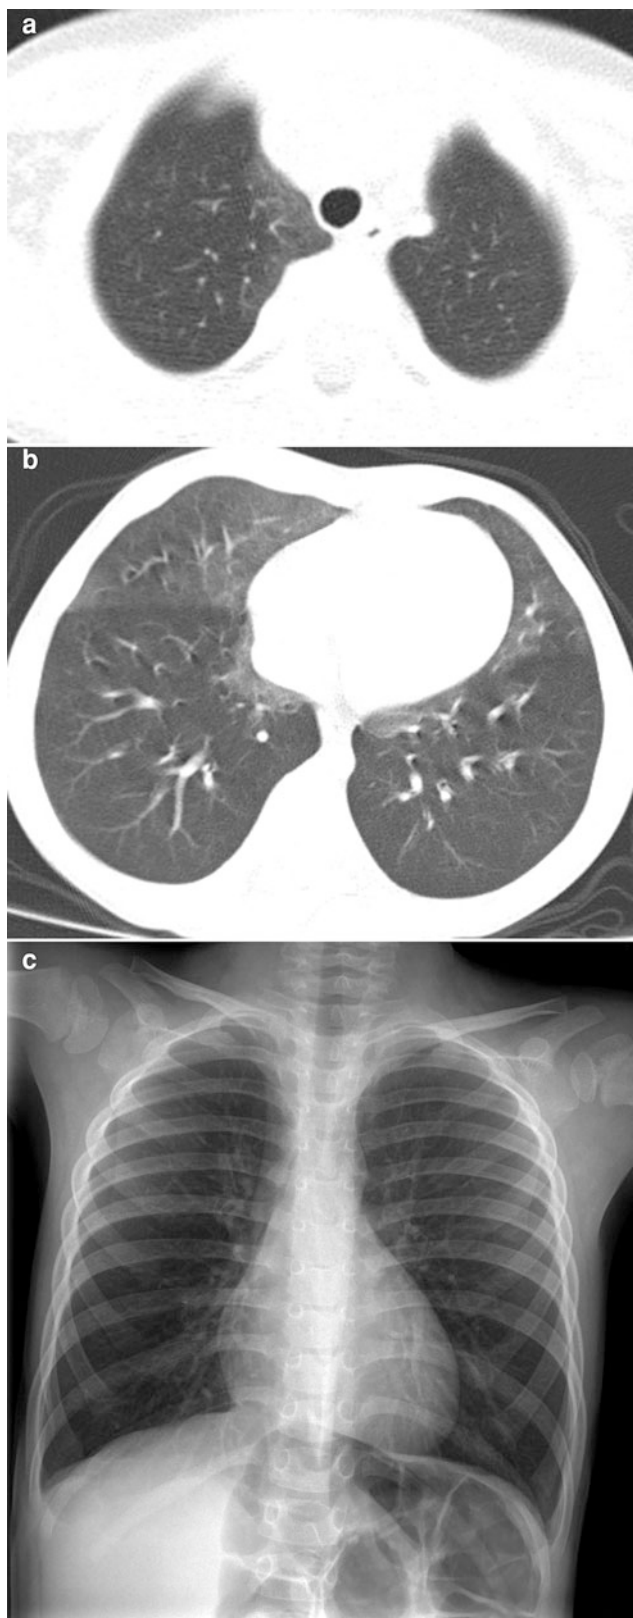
Neuroendocrine cell hyperplasia of infancy. Axial chest CT images (a, b) from a 26-month-old with persistent tachypnea show pulmonary hyperinflation and ground-glass opacities in the right middle lobe, lingula, and paramediastinal regions in a distribution characteristic of neuroendocrine cell hyperplasia of infancy. A frontal CXR (c) obtained at 3 years of age shows continued pulmonary hyperinflation
